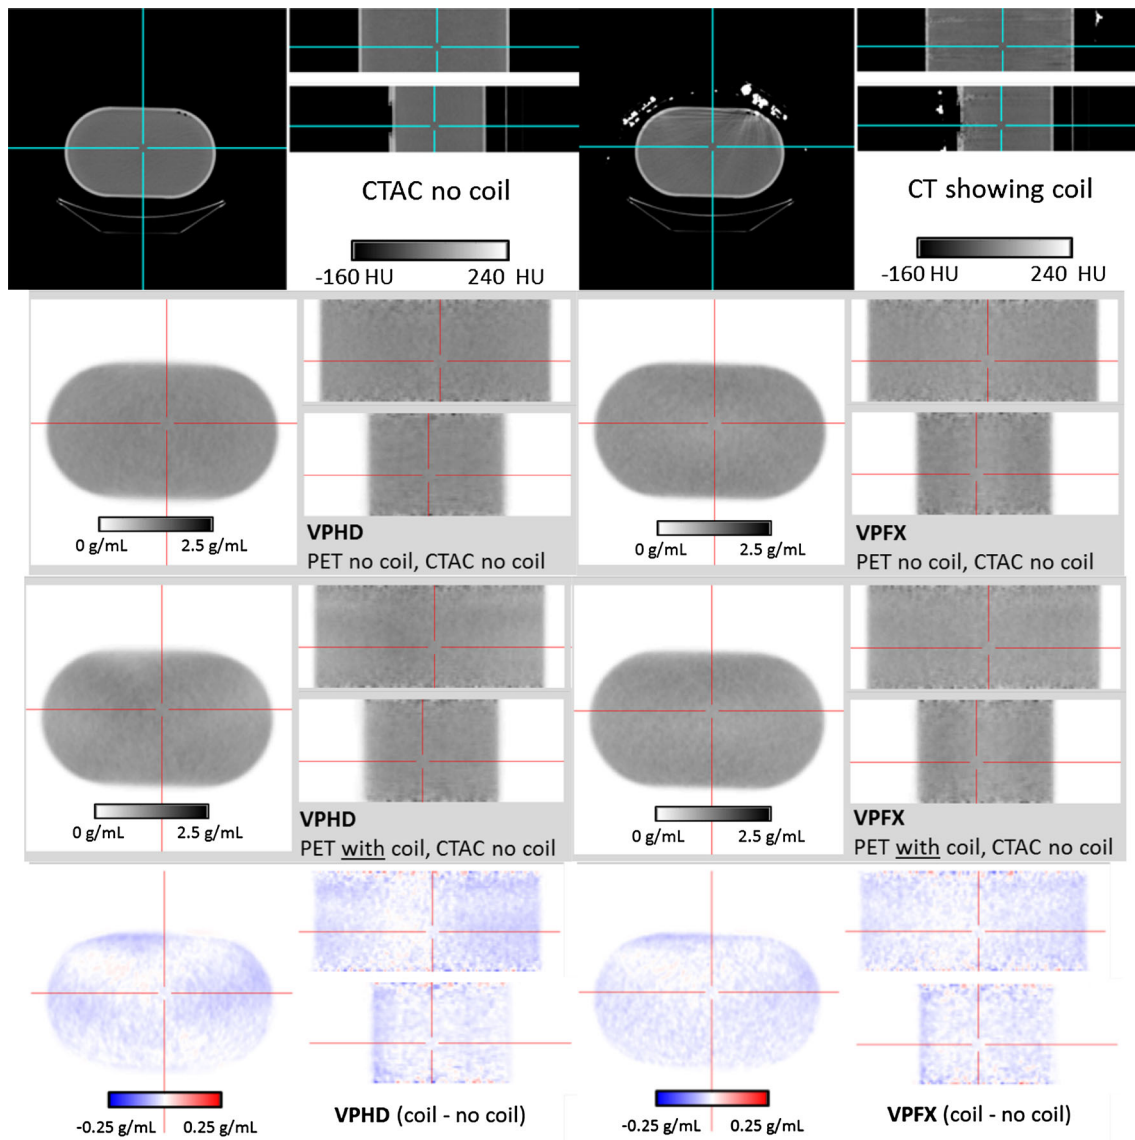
PET/CT images without and with the AA coil present, for a central axial slice location, using non-TOF (*left*) and TOF PET reconstruction. In all cases, the attenuation correction did not include the coil. PET coil/no coil difference images are shown in the *bottom row*
